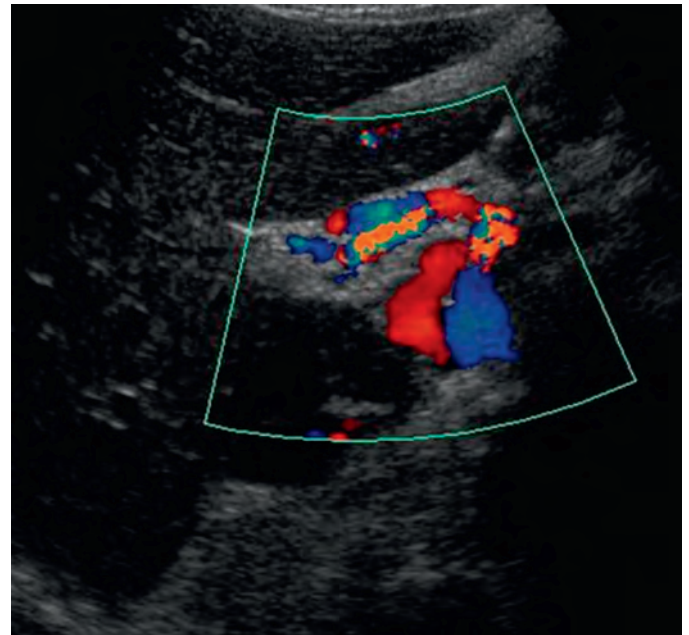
Cavernous transformation of the portal vein: sonographic features. Color Doppler scan shows multiple collateral vessels in the portal vein.
